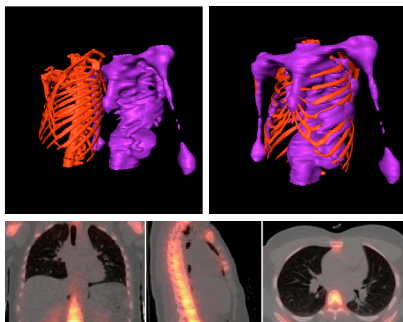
Top left: the 3D fusion of CT and SPECT images from the thoracic study created before registration. The red skeletal structure was generated from the original CT 3D image; the purple from SPECT. Top right: 3D fusion created after registration. Below row: 2D fusions of the registered images shown in coronal, sagittal and axial views (CT image in grey and SPECT in red).
